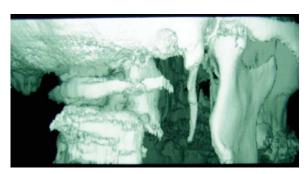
Three-dimensional computed tomography scanning of the styloid process.
